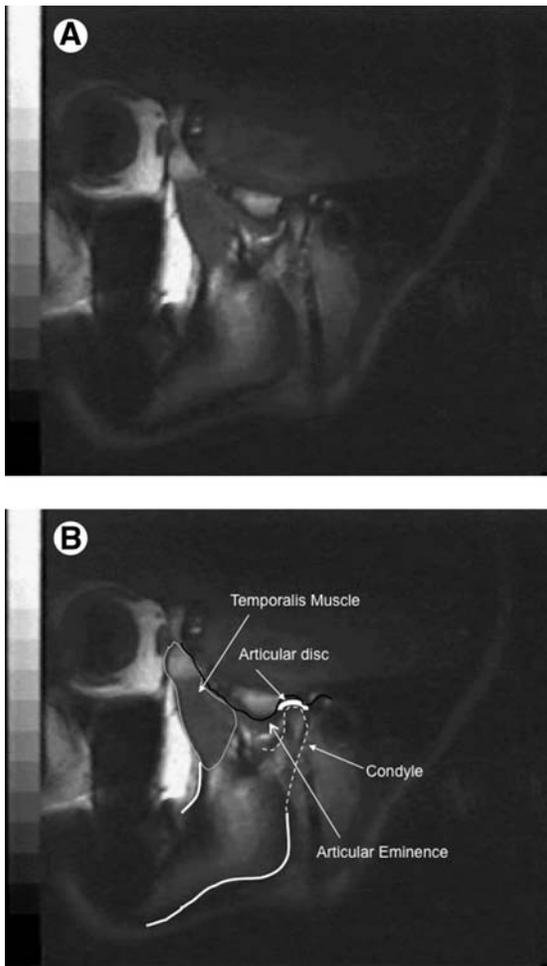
(A) MRI image of a normal TMJ in a closed mouth position presenting a well-defined temporalis muscle, a normal contour of the condyle, articular eminence, glenoid fossa, and a defined articular disk. (B) Outline and labels for A.
